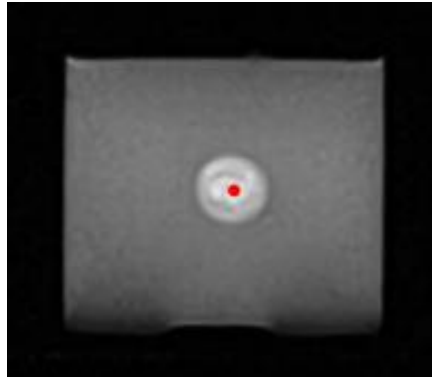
Target location as set on MRI image in the biopsy software (cherry tomato).
